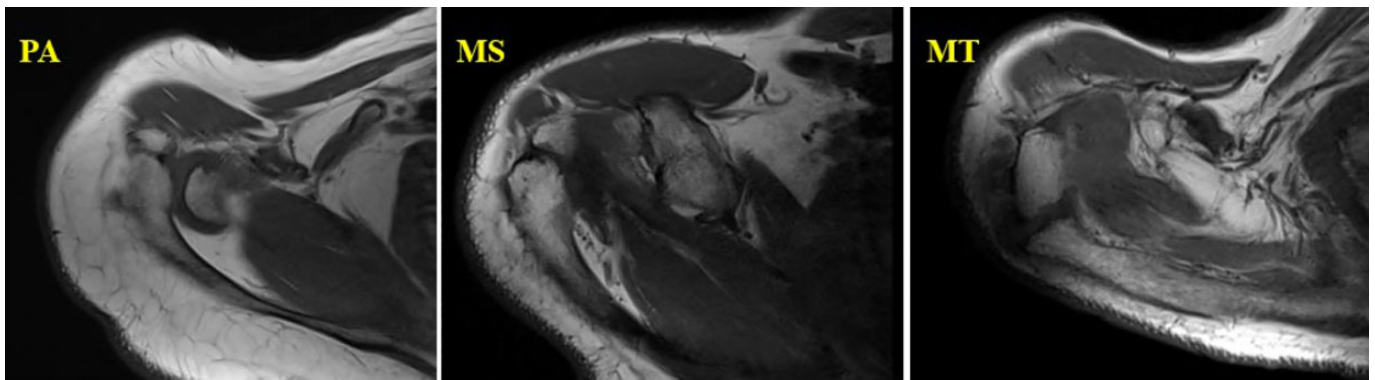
Examples of the 3 types of os acromiale on T1-weighted magnetic resonance imaging of the right shoulder: axial view. MS, mesoacromion; MT, meta-acromion; PA, preacromion.
